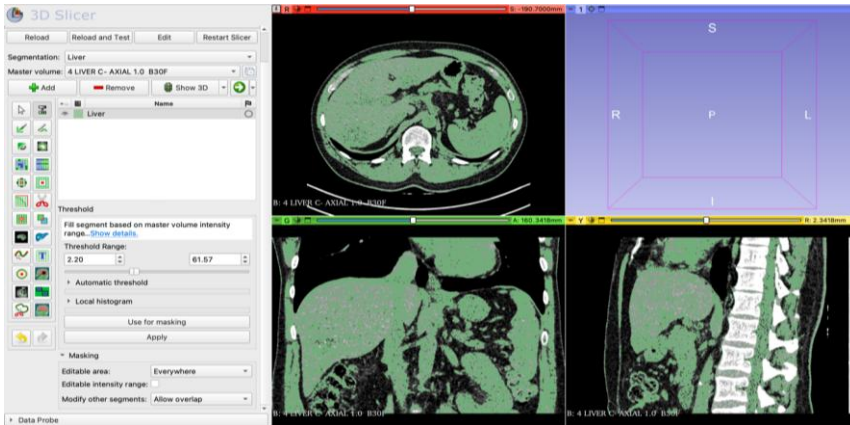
Example of the threshold tool in the Segment Editor module of 3D Slicer which was used for masking to assist segmentation of the liver for the multifocal hepatocellular carcinoma case. A non-contrast CT, viewed in the observation panel was used as the master volume for segmentation.
